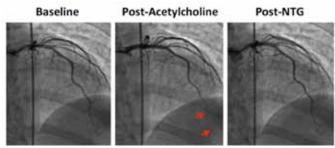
Coronary angiogram and coronary reactivity testing. Coronary reactivity testing is performed with a Doppler wire in the left anterior descending artery. Intracoronary acetylcholine infusion produced vasoconstriction (arrow) of the artery compared to baseline (normal response is dilation), and intracoronary nitroglycerin infusion subsequently dilated the artery with a normal response. Acetylcholine tests endothelialdependent macrovascular and microvascular function.
